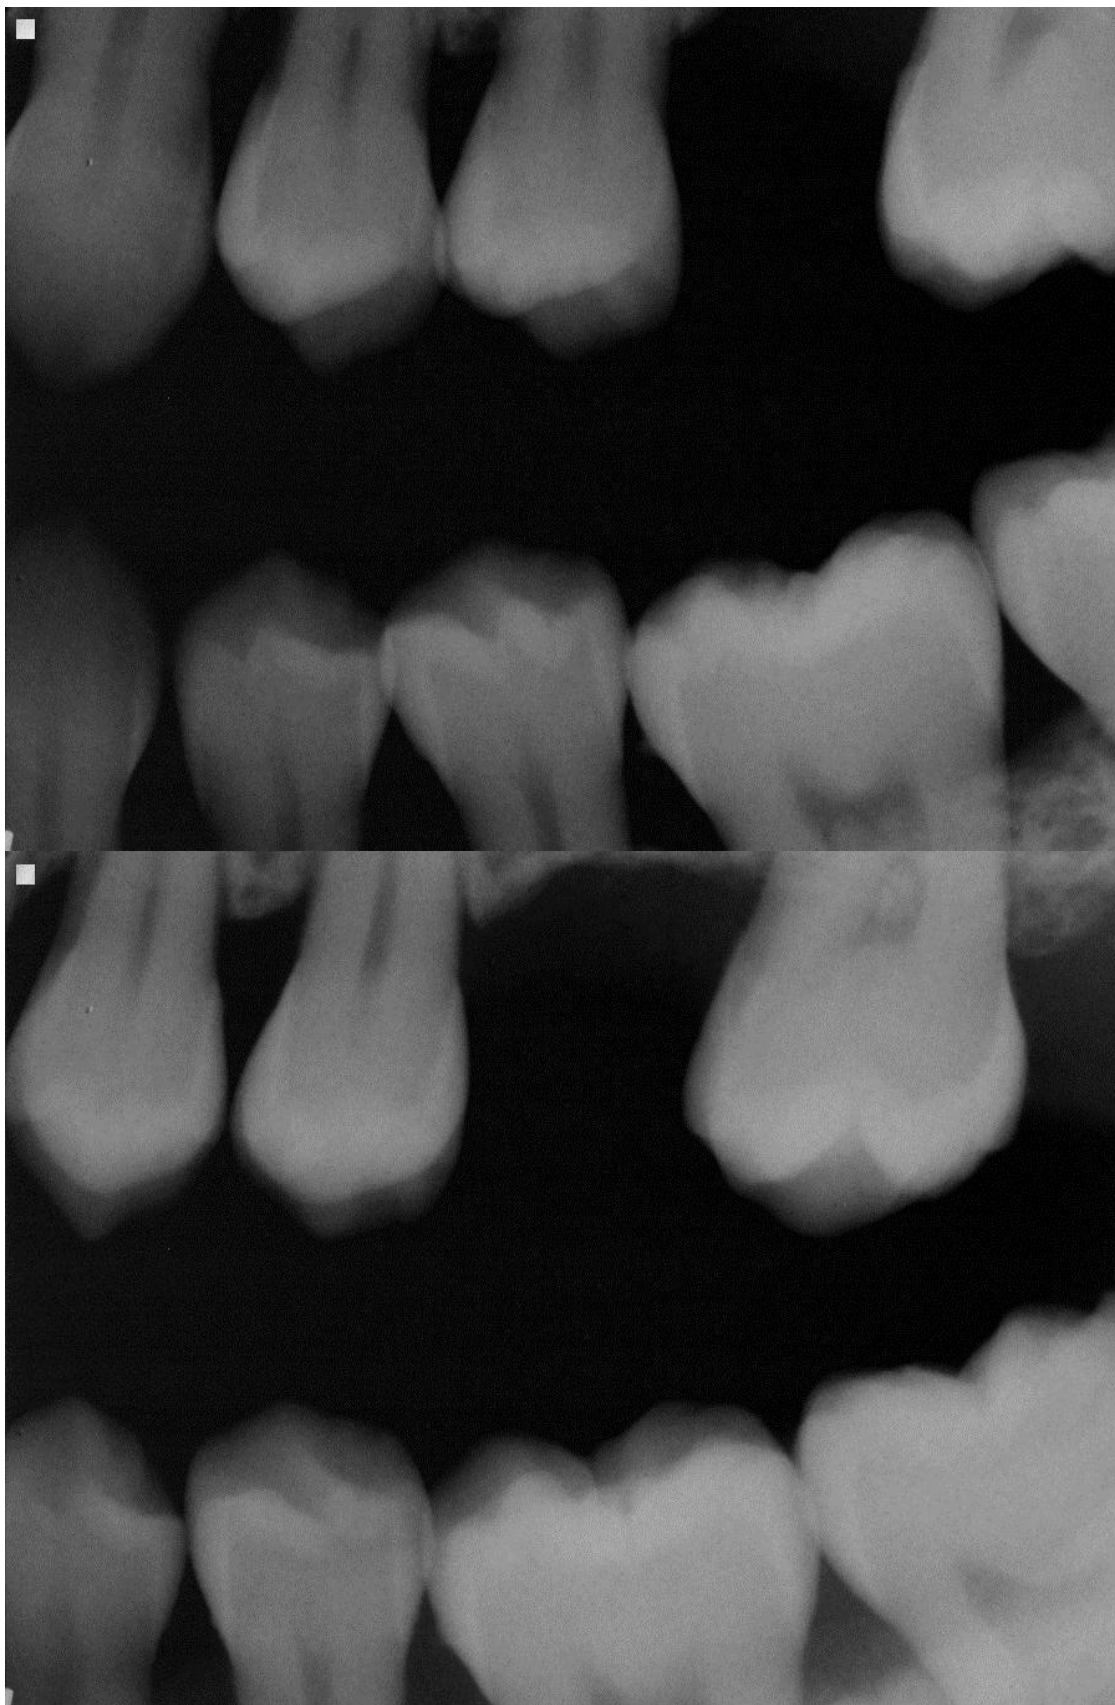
2 Radiographs with evident bone loss.
